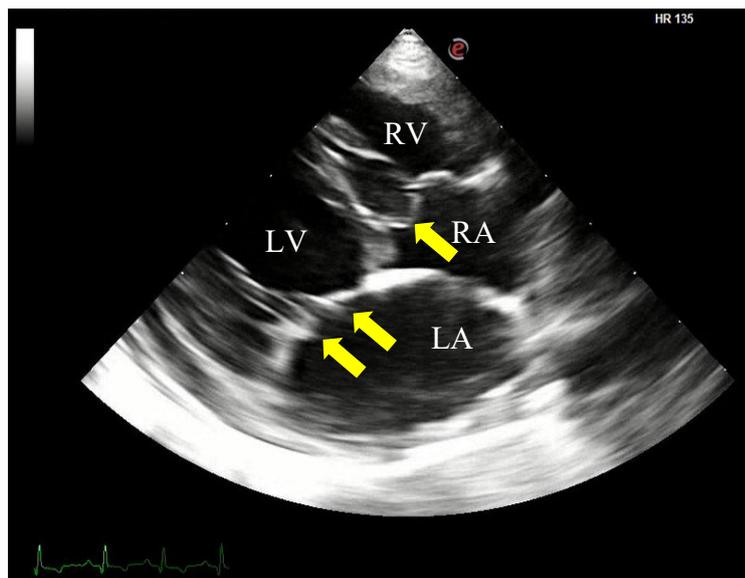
Right parasternal long axis view showing bilateral atrial enlargements and bilateral atrioventricular valve thickening and prolapse. Flail mitral valves and septal tricuspid wave were also observed (arrows).
